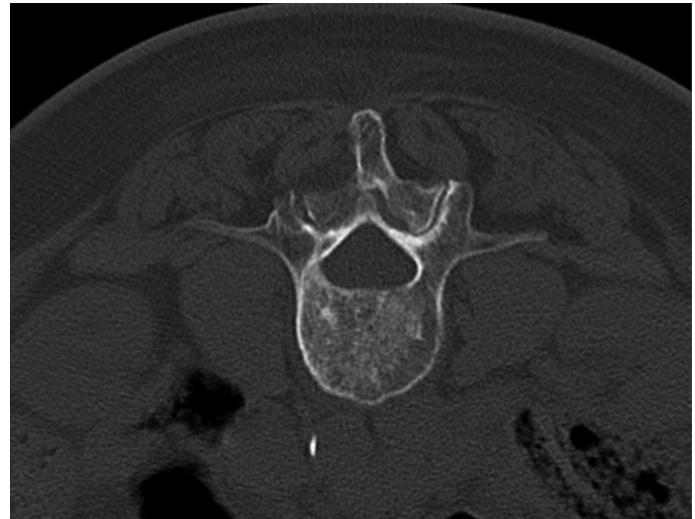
Axial computed tomographic scan of the L3 vertebral body demonstrating focal speckled sclerosis with intervening lucency.
